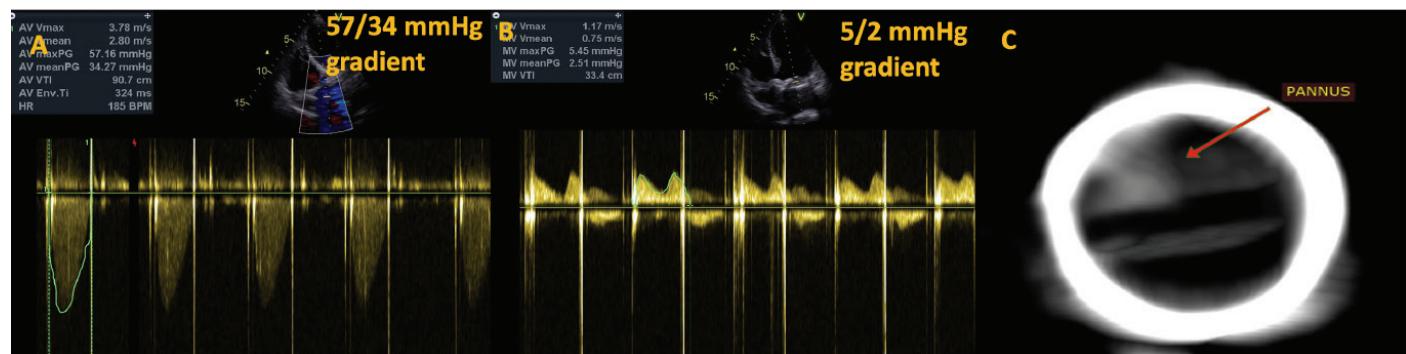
A-B: Transthoracic echocardiographic images of aortic and mitral valve gradient. C; Cardiac computed tomography confirmation of normal leaflet movements and pannus overgrowth
